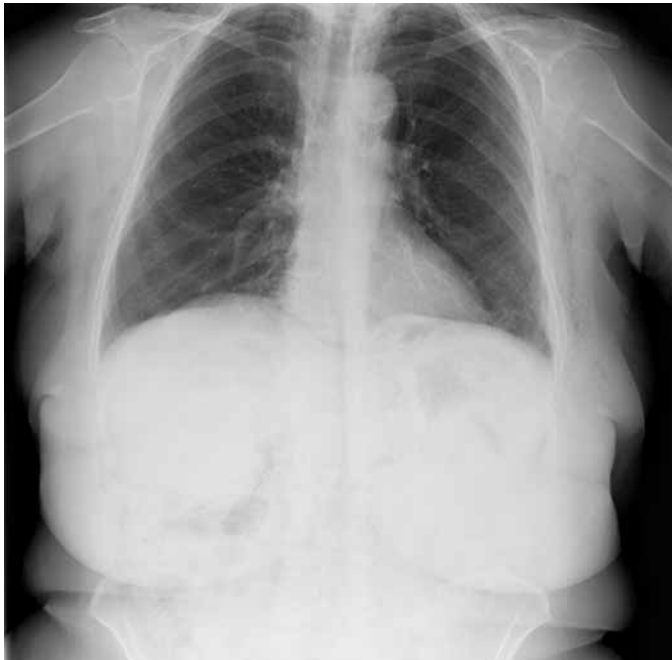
Subcutaneous emphysema on the chest x-ray
